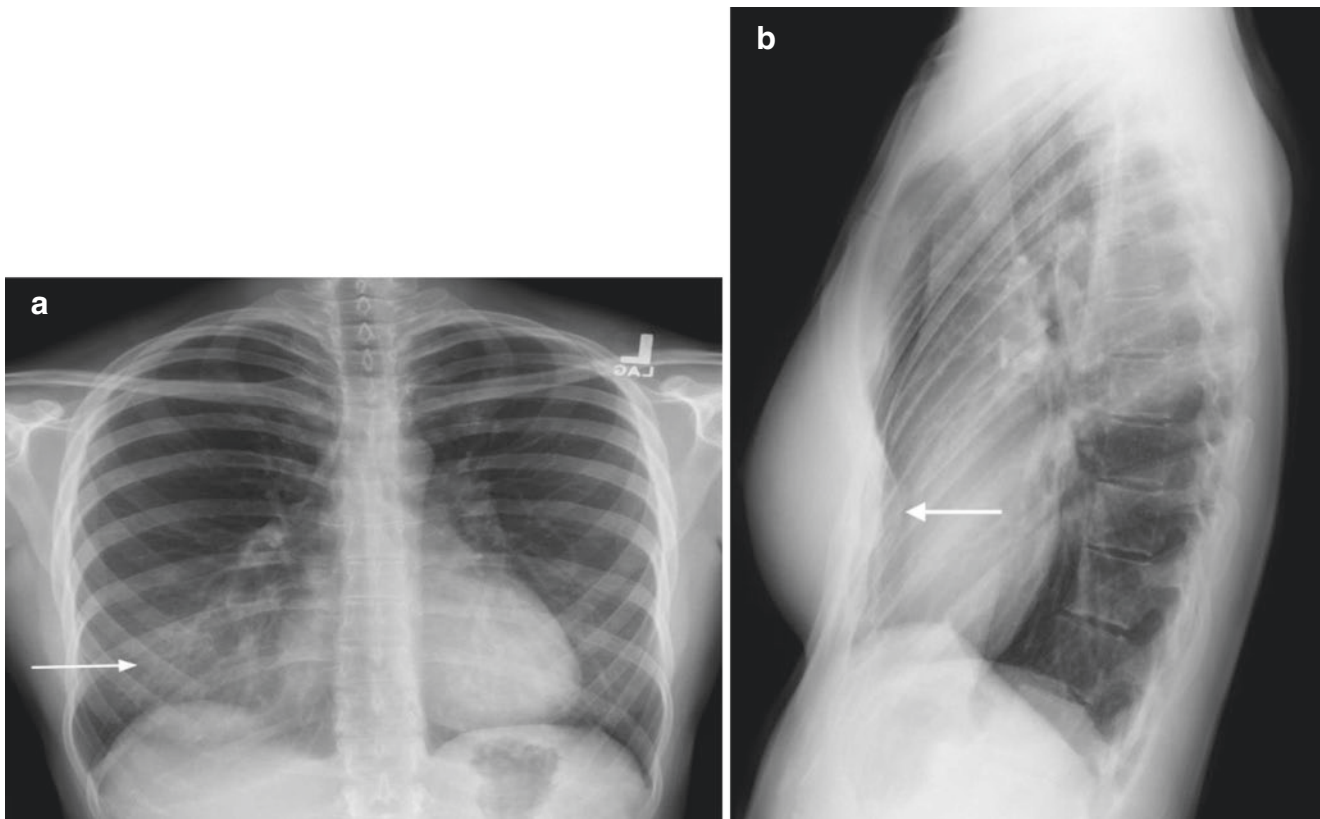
(a, b) Pectus excavatum chest wall deformity mimicking middle lobe disease. (a) Frontal chest radiograph of a 25-year-old female demonstrates a vague opacity overlying the medial right lower lung
